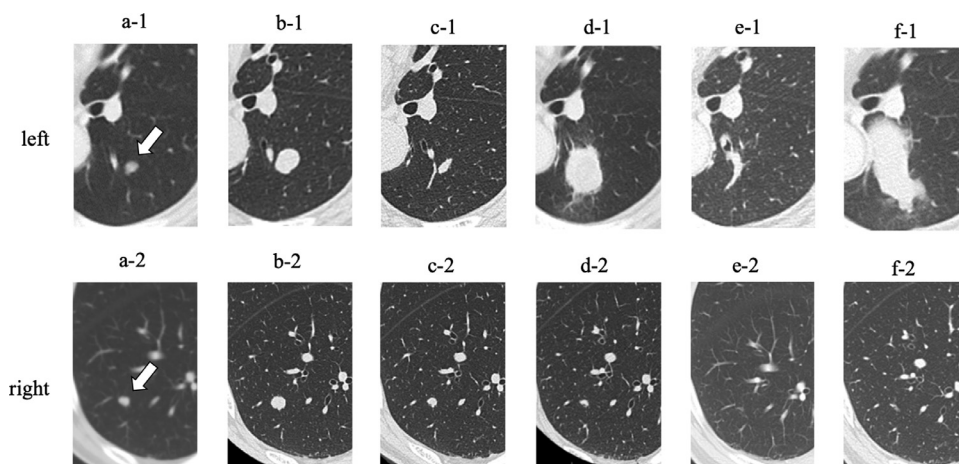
Chest CT images. The changes of CT images after referral our hospital are shown; 0 month (A), 4 months (B), 11 months (C), 17 months (D), 26 months (E), 35 months (F). The upper row shows left lower lobe (A-1 to F-1) and the lower row shows right lower lobe (A-2 to F-2). The arrows indicate the respective lesions. The shape and the size of 2 lung lesions on CT had been changed within 3 years. The maximum diameter: 11mm, 18 mm, 10 mm, 26 mm, none, 43 mm (Fig. A-1, B-1, C-1, D-1, E-1, F-1, respectively), 8 mm, 12mm, 8mm, 8mm, none, none (Fig. A-2, B-2, C-2, D-2, E-2, F-2, respectively). In addition, the concentration (CT value [Hounsfield Unit: HU]) inside the nodule was relatively uniform.
